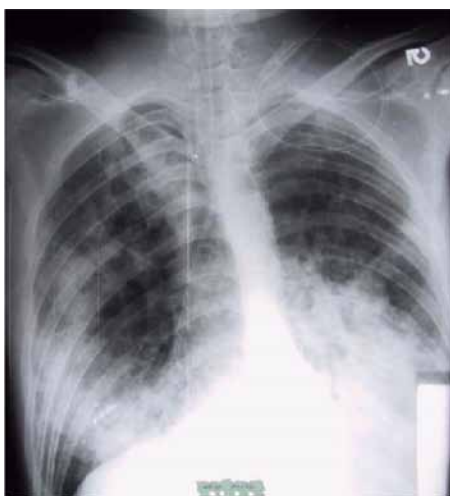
Radiography of thorax finding pulmonary oedema and a right basal pneumopathy. In addition, it shown gastric sound introduced accidentally into bronchial tube.
